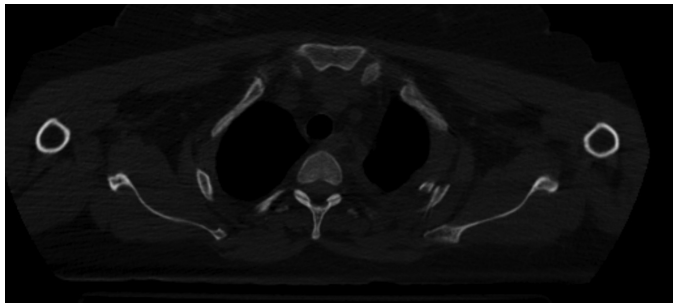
Axial unenhanced chest CT demonstrates fracture of a significantly displaced left second rib. CT, computed tomography.
